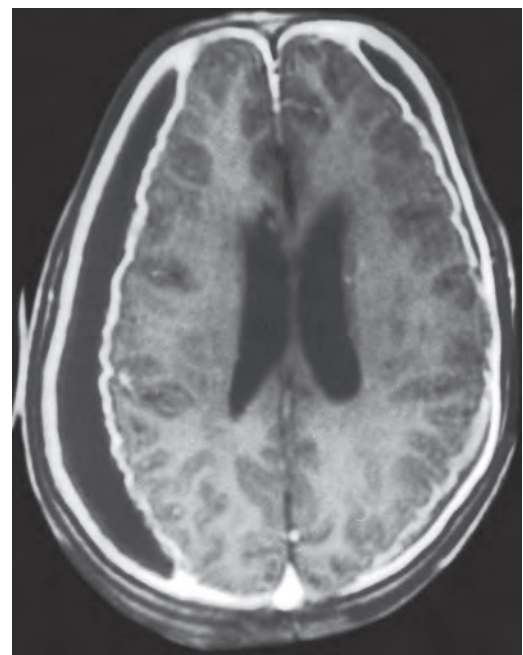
Contrast enhanced MR (T1-weighted image) axial planar imaging showing convexity subdural empyema
